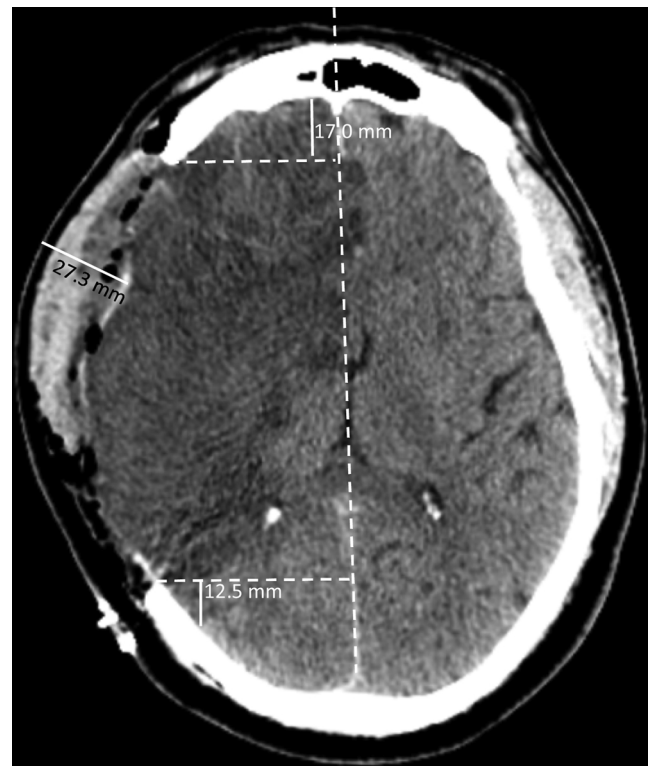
Examples and definitions of the three new CT measurements after hemicraniectomy.
